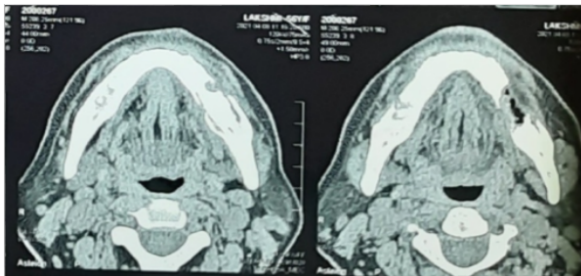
On axial CT - soft tissue window setting reveals soft tissue thickening adjacent to lesion was detected-suggestive of inflammation
